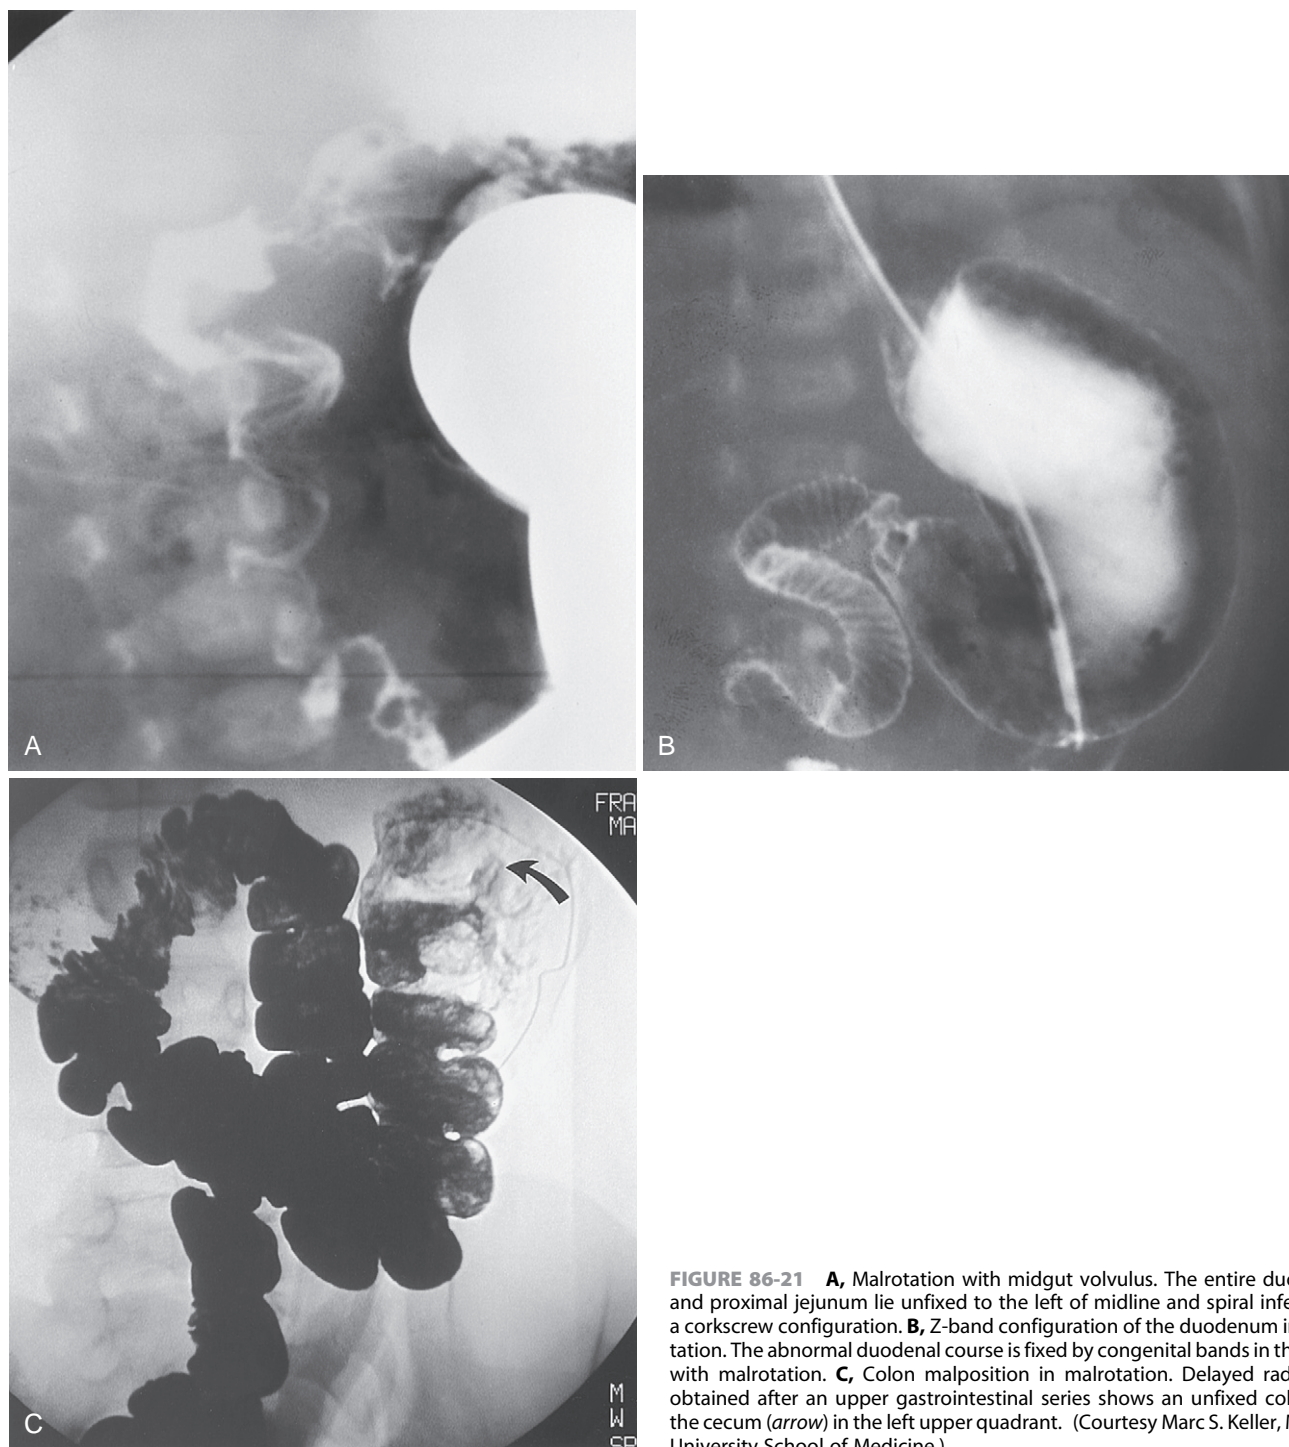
A, Malrotation with midgut volvulus. The entire duodenum and proximal jejunum lie unfixed to the left of midline and spiral inferiorly in a corkscrew configuration. B, Z-band configuration of the duodenum in malrotation. The abnormal duodenal course is fixed by congenital bands in this infant with malrotation. C, Colon malposition in malrotation. Delayed radiograph obtained after an upper gastrointestinal series shows an unfixed colon with the cecum (*arrow*) in the left upper quadrant. (Courtesy Marc S. Keller, MD, Yale University School of Medicine.)
